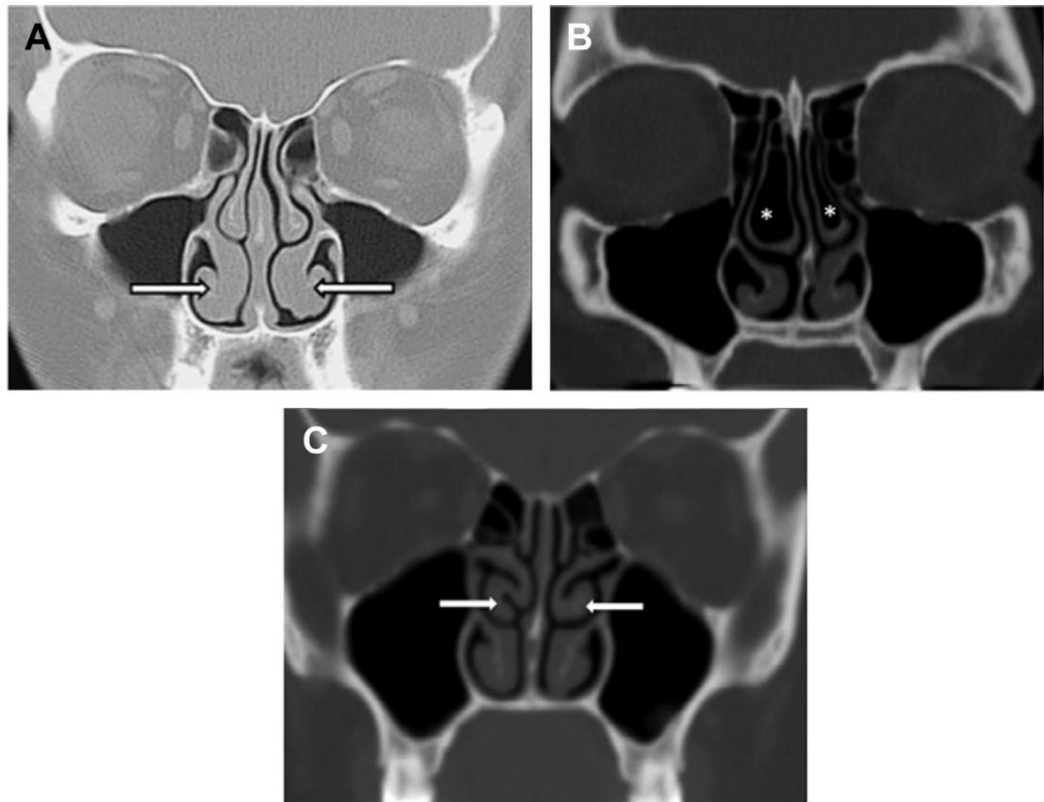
(A) Coronal computed tomography (CT) showing bilateral inferior turbinate with mostly soft tissue hypertrophy (white arrows). (B) Coronal CT showing bilateral concha bullosa (white asterisks). (C) Coronal CT showing bilateral paradoxical middle turbinate (white arrows). Taken from: Hsu DW, Suh JD. *Anatomy and Physiology of Nasal Obstruction*, Otolaryngologic Clinic of North America 2018.
